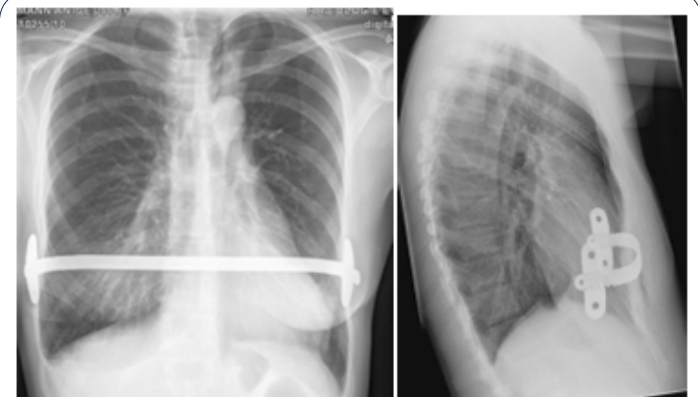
Chest X-ray in posterior-anterior and lateral position after correction using the old pectus bar.
